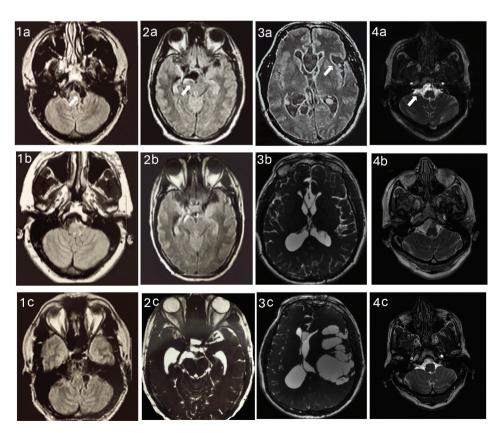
MRI images from patients (#1 to #4) with subarachnoid neurocysticercosis (NC) at initial presentation (a) Arrows point the cysts), after treatment (b) and at relapse (c).
